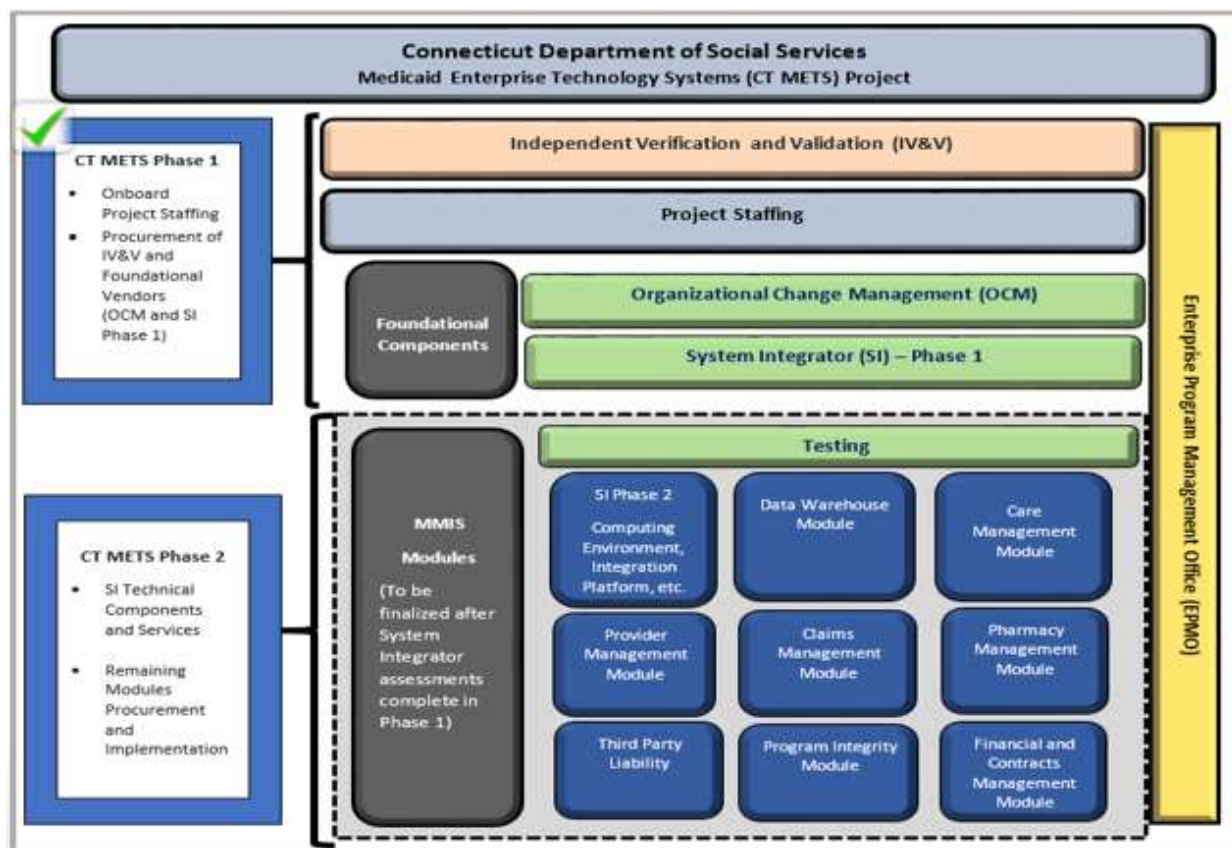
CT METS Phased Approach
